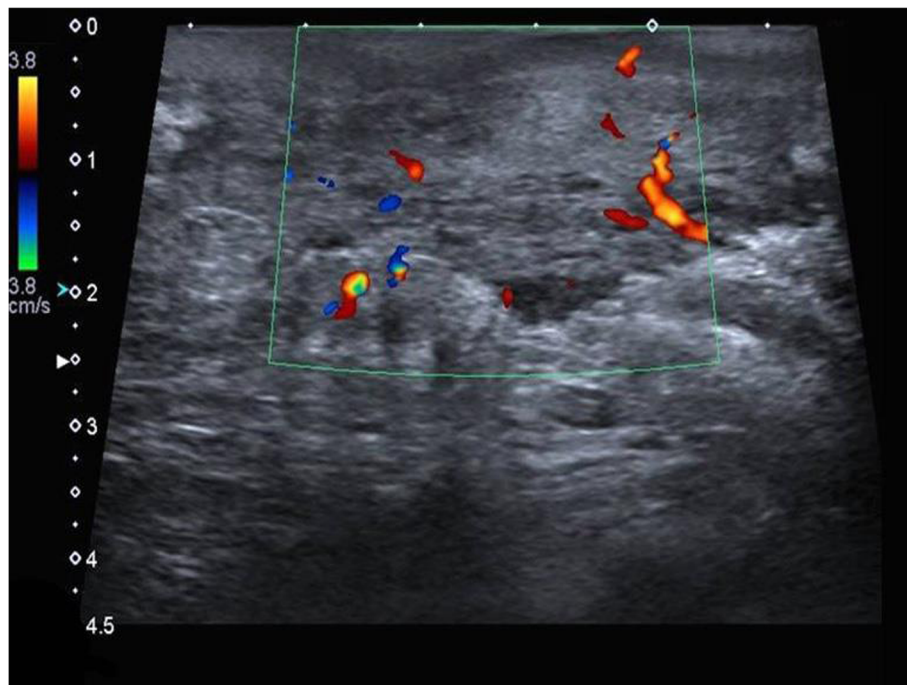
B-mode ultrasound showed an ill-defined area of parenchymal distortion with marked internal vascularity, no definite masses, assessed as BIRADS 4C. Pathology: DCIS (grade II). Biological markers: ER positive, PR negative, HER/neu-2 positive, and Ki67 positive
